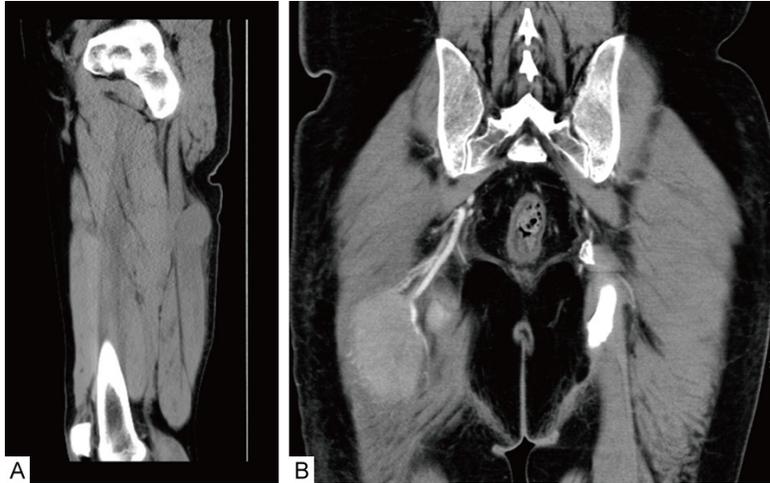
CT images of skeletal muscle metastases. CT scan of the right thigh shows oval mass with 3.2 cm in diameter (A); Pelvic CT shows the abnormal enhanced soft tissue mass in the right gluteus maximus (B).
